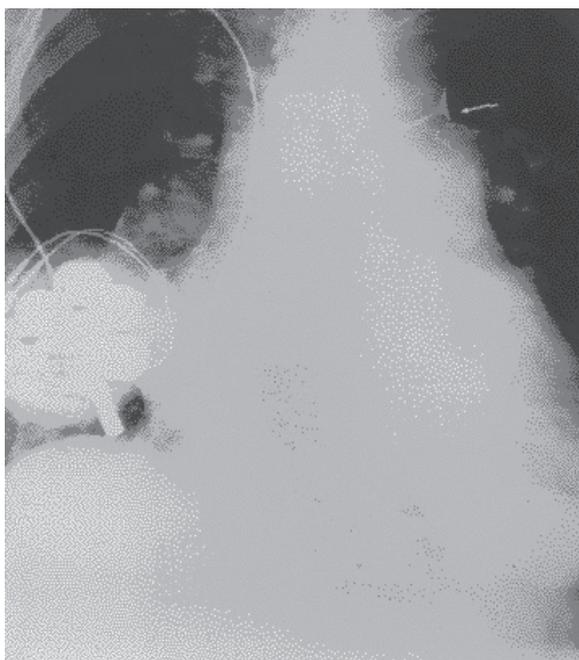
Chest x-ray showing calcification of the ductus. Reprinted with permission of the American College of Cardiology.
